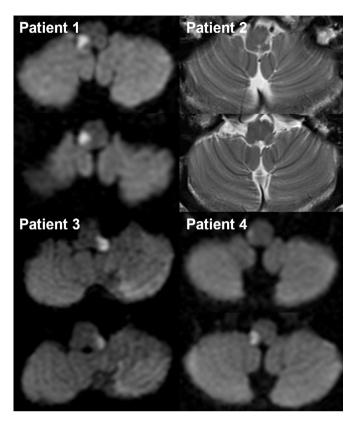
Neuroimaging of the four patients who presented with dorsolateral medullary infarction. Diffusion-weighted (patients 1, 3, and 4) or T2-weighted (patient 2) brain magnetic resonance imaging shows high signal intensity lesions involving the unilateral dorsolateral medulla. An additional lesion in the ipsilateral cerebellar hemisphere is also observed in patient 3.
